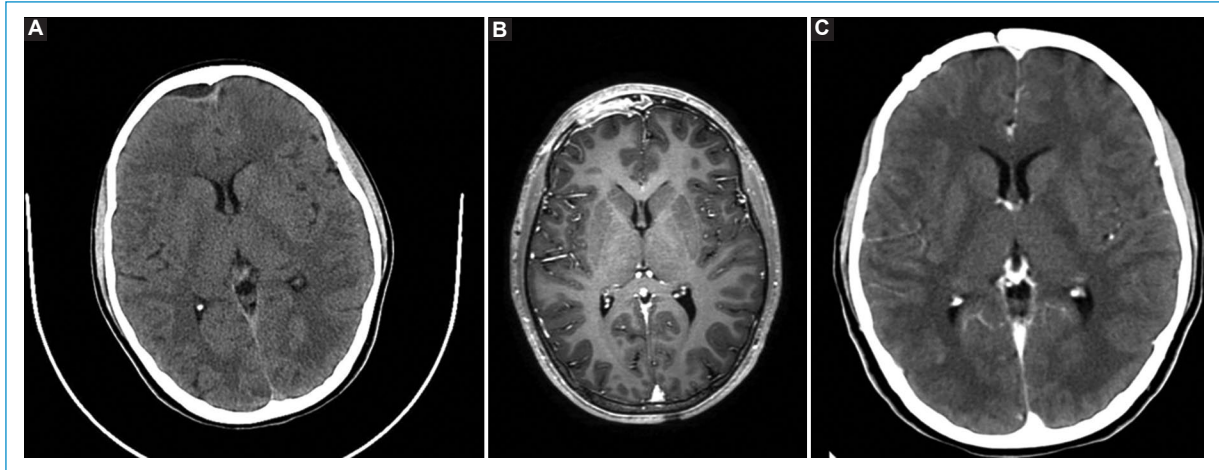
Epidural empyema in a 13-year-old girl (case 1). (A) axial CT scan showing a right-sided extra-axial frontal infectious collection; (B) axial T1 MRI with gadolinium on day 24 of antibiotic therapy (day 10 of linezolid) and (C) axial CT scan with contrast, eight weeks after completing the antibiotic therapy regimen with prior empyema surgical drainage.
